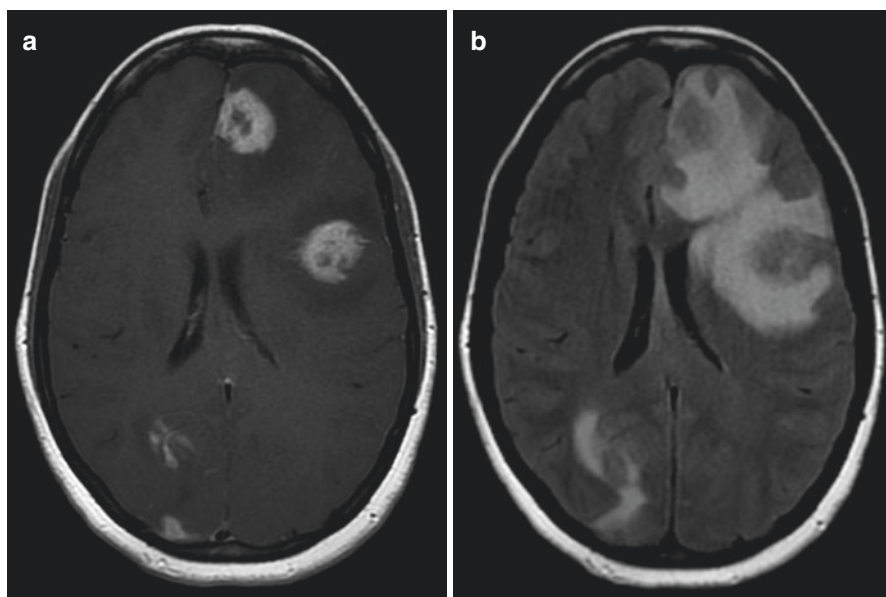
A 40-year-old female status post renal transplant with CNS PTLD. (a) Contrast-enhanced T1-weighted image shows multiple enhancing brain masses in the subcortical white matter. Note the central necrosis resulting in ringlike enhancement. (b) Fluid attenuation inversion recovery image shows prominent vasogenic edema surrounded the lesions
